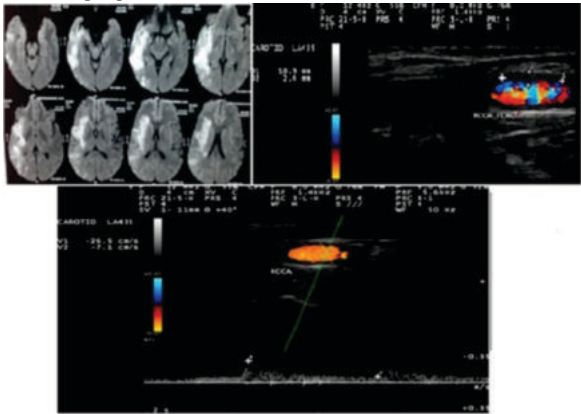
MRI plate showing acute ischaemic infarct involving right side, Colour Doppler sonography image showing homogenous hypoechoic smooth plaque in Right CCA, Colour Doppler sonography image of same case showing spectral broadening
